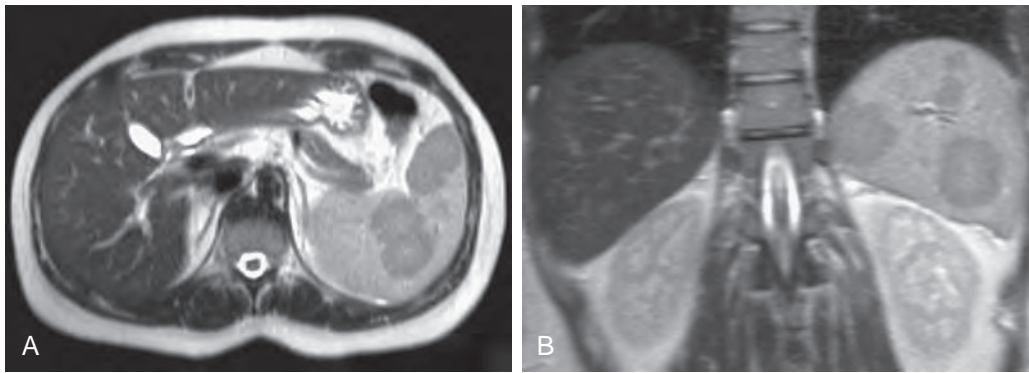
Lymphoma. Axial (A) and coronal (B) half-Fourier acquisition single-shot turbo spin-echo (HASTE) MR images demonstrate low signal intensity masses in the spleen of a 32-year-old pregnant woman with a low-grade lymphoma. (Courtesy D. Vanbeckevoort, MD, Leuven, Belgium.)
